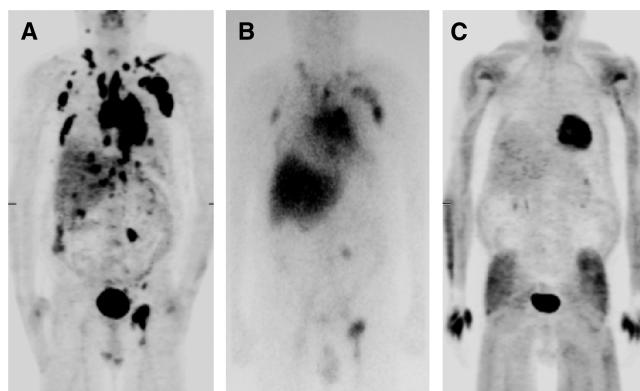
Follicular lymphoma in a 61-year-old patient with relapsing disease with ^{177}Lu -DOTA-rituximab. (A) ^{18}FDG PET shows disseminated partly bulky relapsing disease. (B) ^{177}Lu scintigram 4 days after ^{177}Lu -DOTA-rituximab depicts distribution of ^{177}Lu in tumor masses. (C) Repeated ^{18}FDG PET 2 months after radioimmunotherapy shows complete remission. Reprinted with permission from ref 263. Copyright 2013 Society of Nuclear Medicine and Molecular Imaging, Inc.
